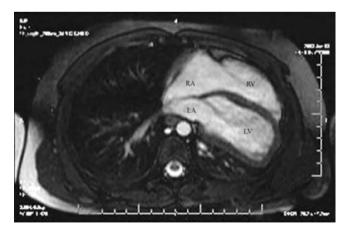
Cardiac MRI of absent pericardium with unusual leftward and posterior shift of the heart and absence of a visible pericardium. On cine imaging, the ventricles are unusually mobile and the typically seen pericardial fluid (normally clearly visible during systole) is absent (courtesy of MS. Cohen, MD). *LA* left atrium; *LV* left ventricle; *RA* right atrium; *RV* right ventricle
